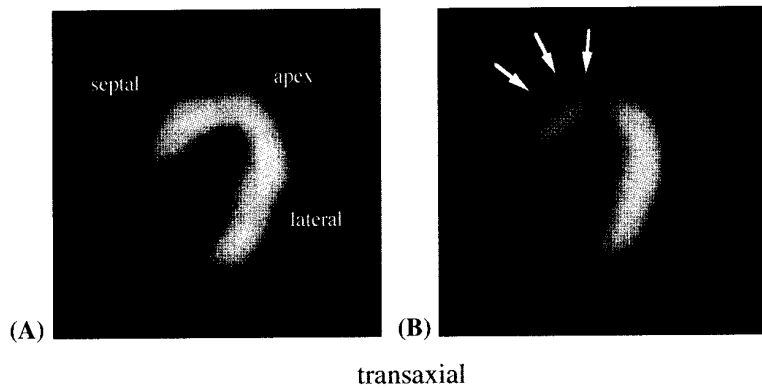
Case 1. ²⁰¹Tl myocardial scintigrams at rest (A) and after dipyridamole infusion (B), showing a reversible perfusion defect in the septum.
